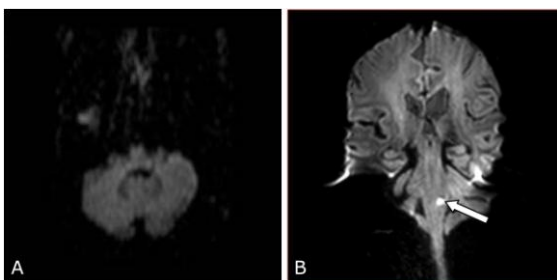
Acute ischemic infarction in the left medulla oblongata in a patient aged 62 years suffered from hemiplegia; A) On standard axial 5 mm DWI, the ischemic lesion is not visible; B) On thin-section coronal 3 mm DWI, the ischemic lesion is delineated
